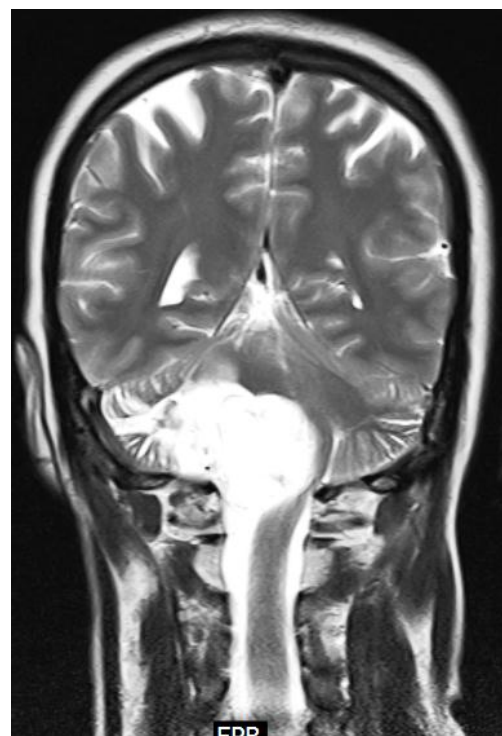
MRI shows high intensity lesion in the right CPA
